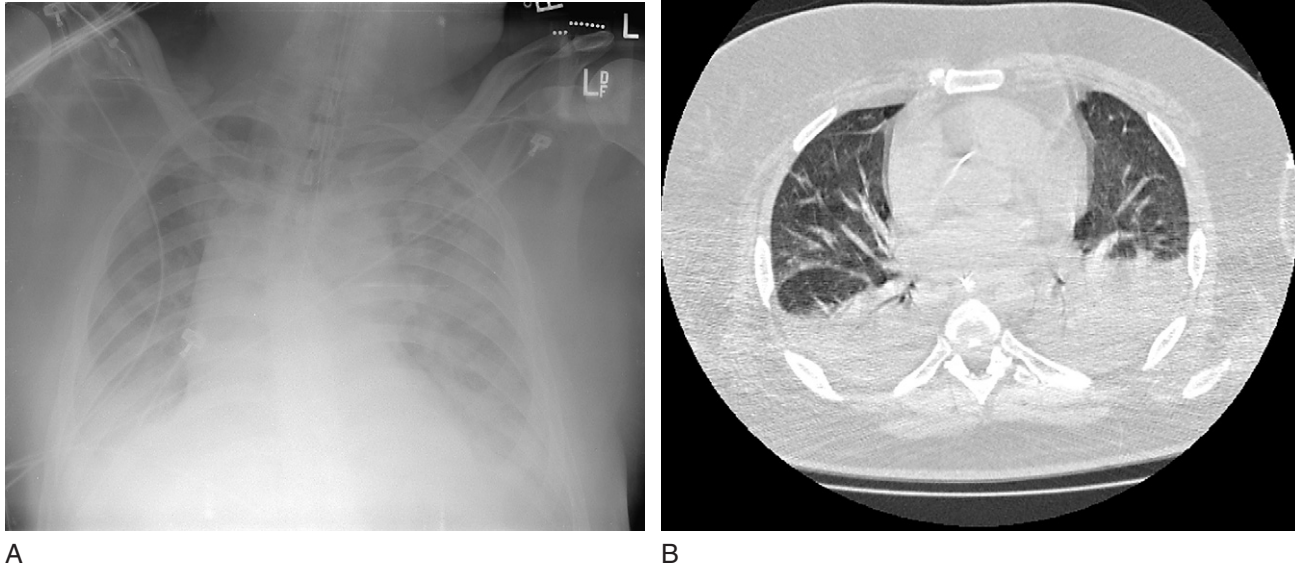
A, The chest radiograph of a 54-year-old man with acute respiratory distress syndrome of unknown cause demonstrates diffuse opacification of all quadrants. B, A computed tomography scan demonstrates marked heterogeneity of parenchymal involvement, with dense consolidation posteriorly, and with air bronchograms evident. The anterior lung areas are relatively spared.
